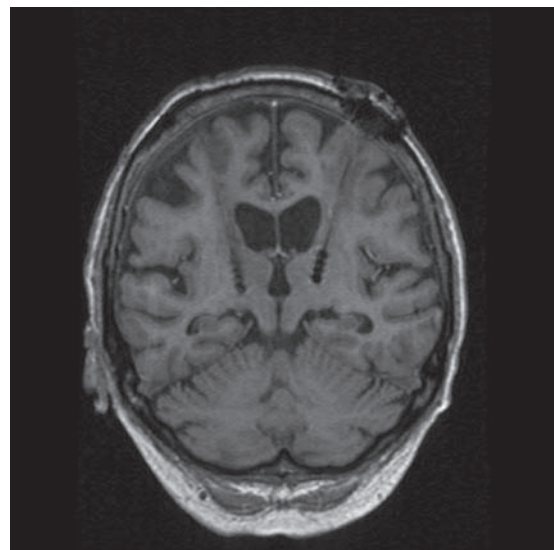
Coronal T2-weighted magnetic resonance image demonstrating bilateral electrode placement in the thalamus.
